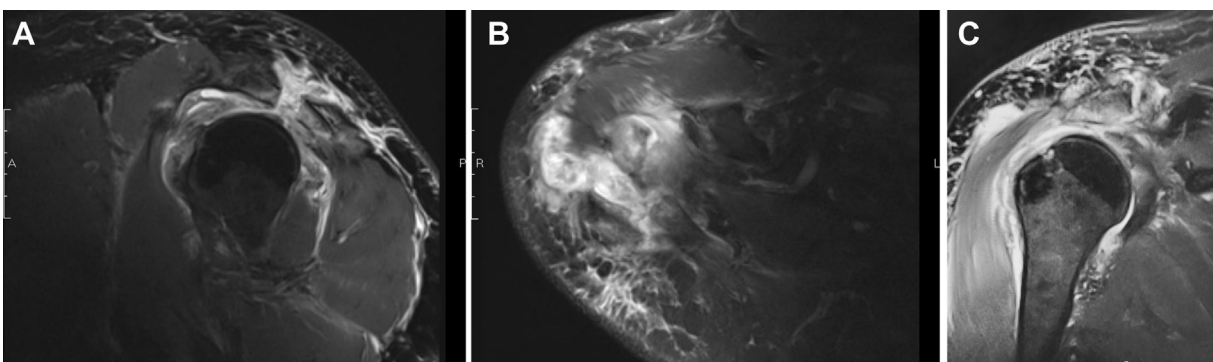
Preoperative MRIs. (A) Sagittal noncontrast MRI demonstrating acute acromion fracture. (B) Axial noncontrast MRI demonstrating acute acromion fracture. (C) Coronal noncontrast MRI demonstrating acute rotator cuff tear at the level of the supraspinatus tendon. MRI, magnetic resonance imaging.
